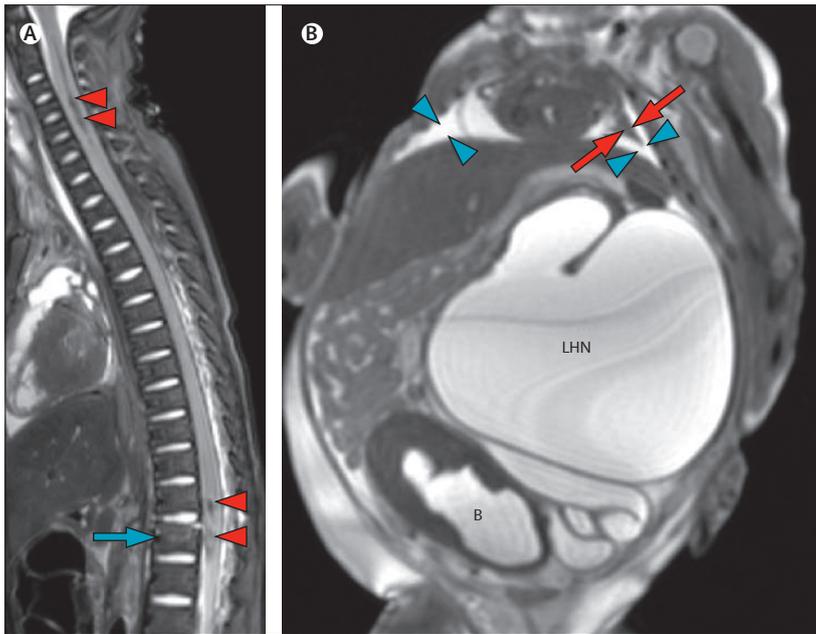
Pathological abnormalities on post-mortem MRI
